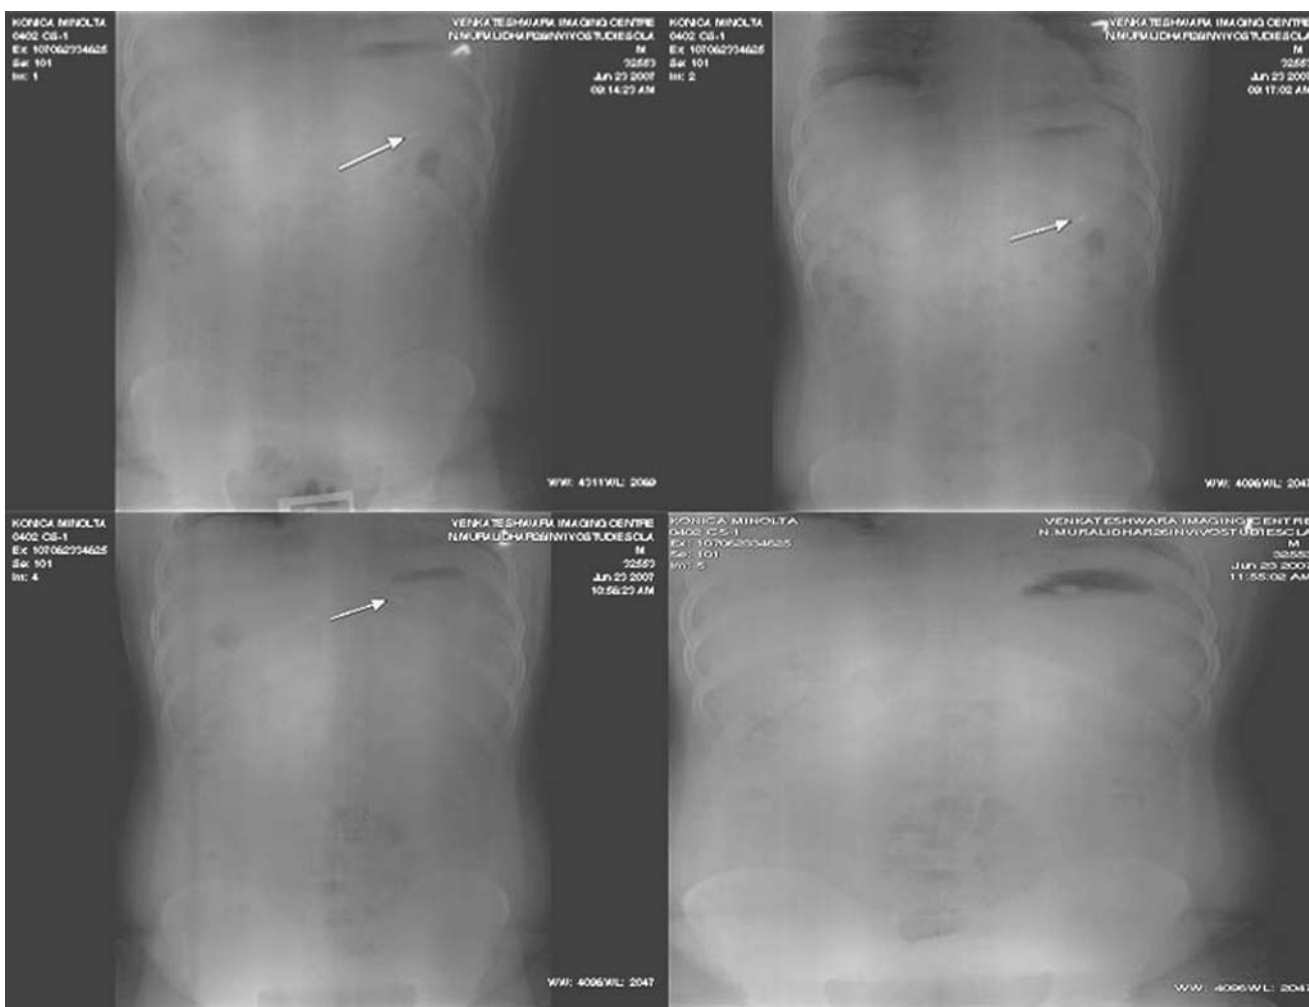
A representative radiographic images showing the presence of BaSO<sub>4</sub> loaded floating tablet in the stomach at different time periods (tablet is pointed by an arrow)
